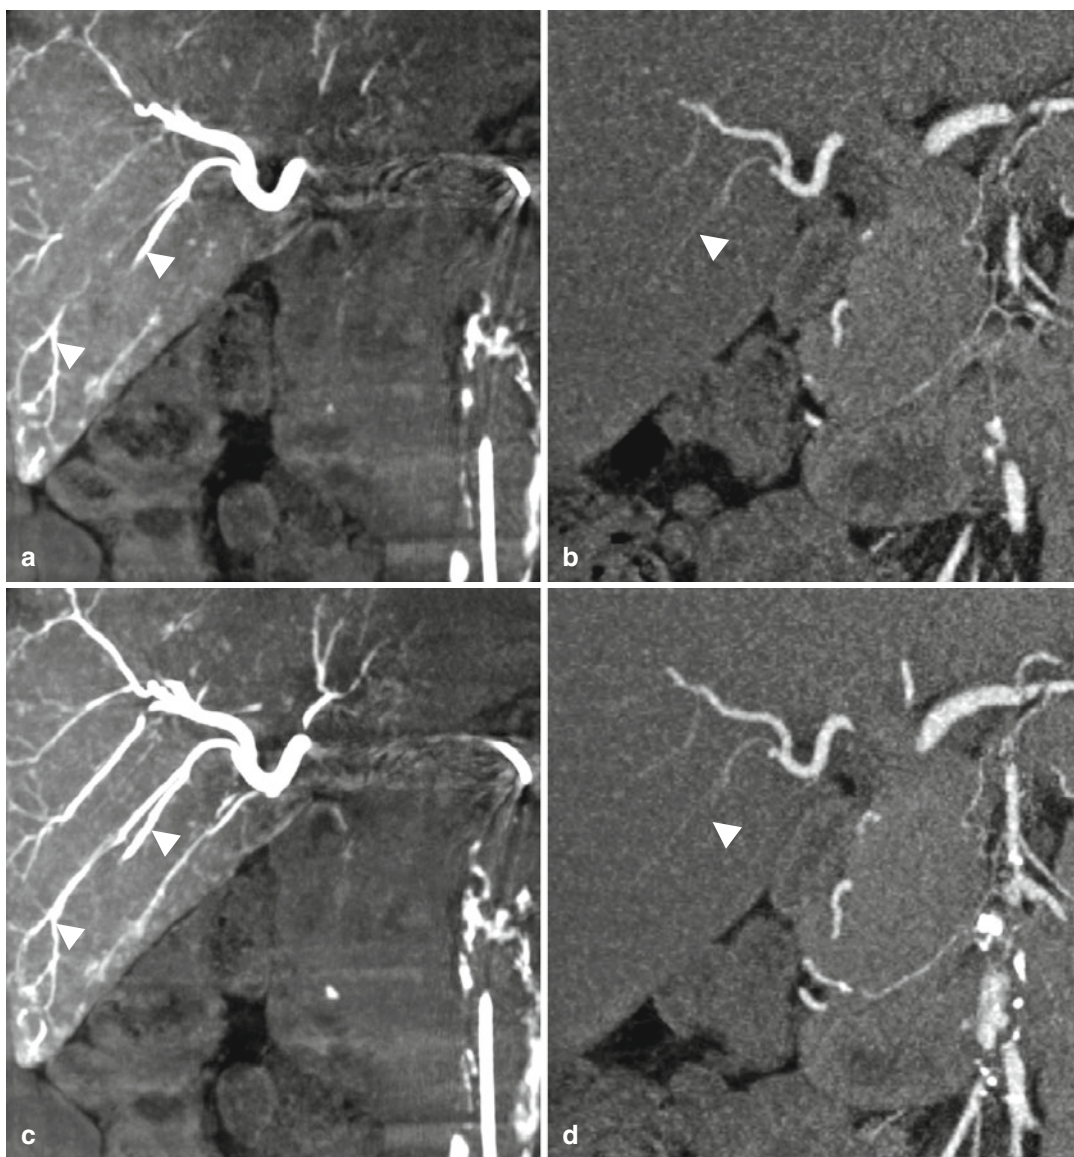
(a, c, e) C-arm CT and (b, d, f) MSCT of the liver in the arterial phase prior to chemoembolization. Due to the different forms of contrast material administration (intravenously in MSCT, intra-arterially via the common hepatic artery in C-arm CT), a significant higher artery-to-liver contrast is obtained in C-arm CT. (a, b) 5-mm and (c, d) 10-mm coronal maximum intensity
